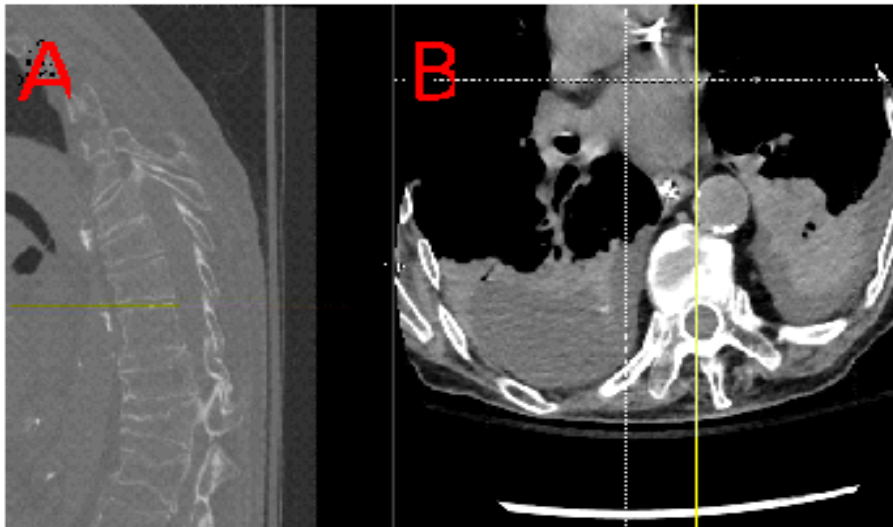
Pre-operative baseline thoracic computed tomography (CT) scan. Panel A. Sagittal view of thoracic spine demonstrates significant kyphosis and scoliosis, with chronic compression fracture of T8-T10. Panel B. Axial view at T6-T7 disc space demonstrates significant spinal rotation to the left.
